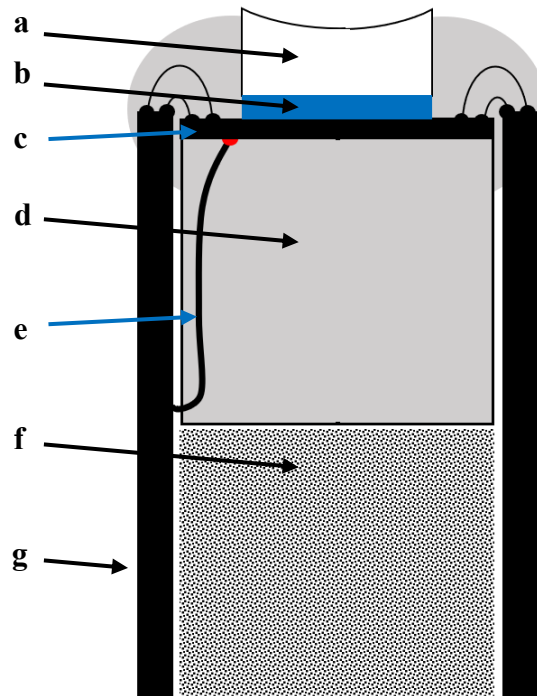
A depiction of the array stack-up used within the developed ultrasonic transducer. The acoustic lens (a) focuses the sound energy emitted by the piezoelectric wafer (c) and transmitted by the acoustic matching layer (b). The electrical interconnects (g) are bonded to the array elements through wirebonds and the acoustic backing layer (d) provides structural support and acoustic tuning for the array. The electrical return path is completed through a ground wire (e).
